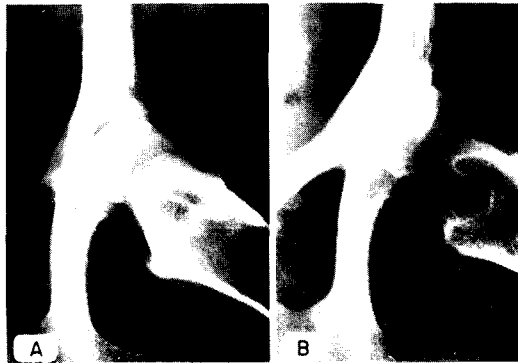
Radiographs show A, normal femur and B, femur with lesion in neck region.
